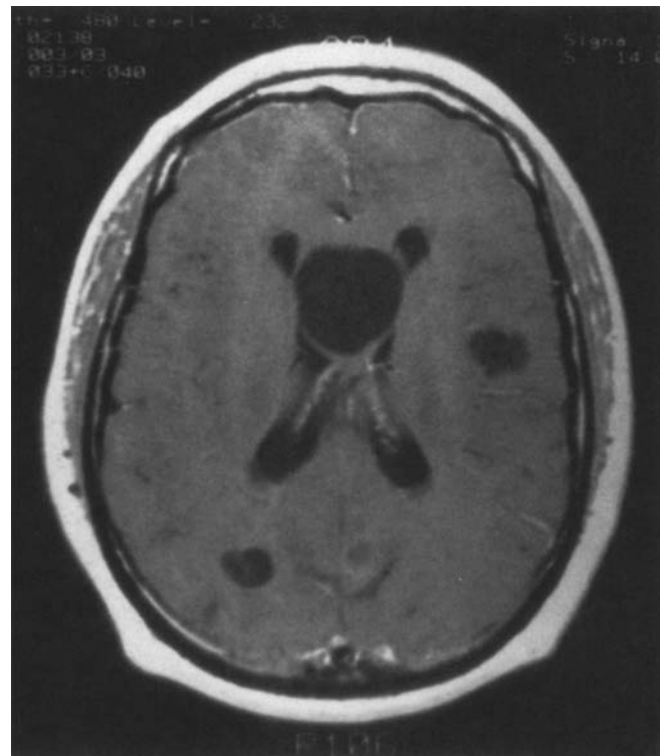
Axial T₁-weighted MRI with gadolinium shows multiple active inflammatory, parenchymatous, and intraventricular cysts in a 46-year-old man who presented with headaches and tonic clonic generalized seizures.
